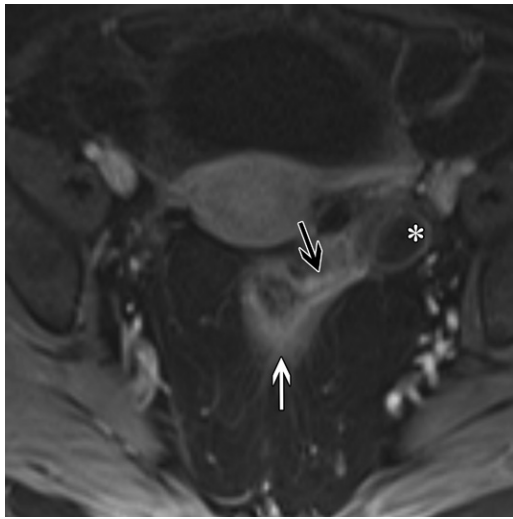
Rectal-adnexal fistula in a 39-year-old woman with Crohn disease. Axial contrast-enhanced T1-weighted MR image shows diffuse thickening and mucosal enhancement of the rectum (white arrow). A fistula (black arrow) extends from the rectum to the adjacent left adnexal tissue, which resulted in a hydrosalpinx (*).
